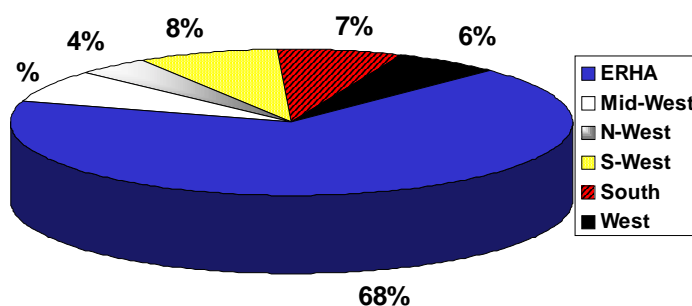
Geographic distribution of reported cases of CT 1995-9 (n=2586).
